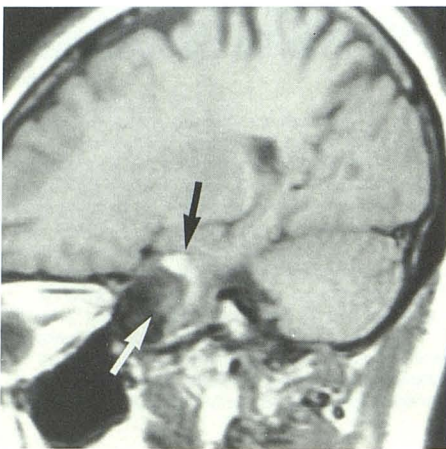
54-year-old woman with 3.5-cm right carotid-ophthalmic artery aneurysm. T1-weighted sagittal MR image (SE 600/20). Persistent heterogeneous signal intensity (*white arrow*) is noted within patent lumen due to slow flow. Similar findings were also noted on T2-weighted sequences (not shown). A thick rim of high intensity (*black arrow*) possibly representing methemoglobin (see also Fig. 5C), which can be confused with flowing blood on cine MR, is seen within thrombus.
